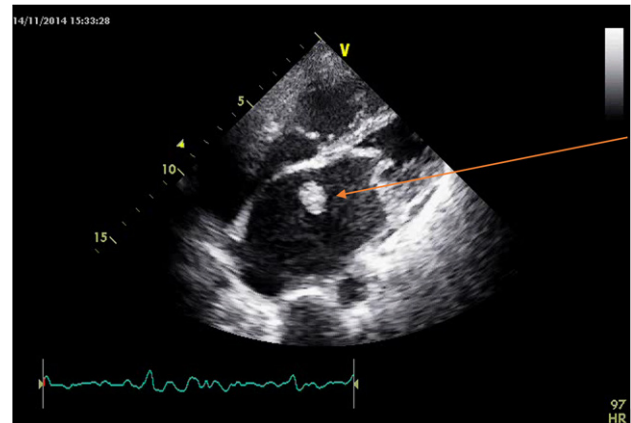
Echocardiogram image 2 – showing a large spherical ball of thrombus (orange arrow) floating freely inside the grossly dilated left atrium
